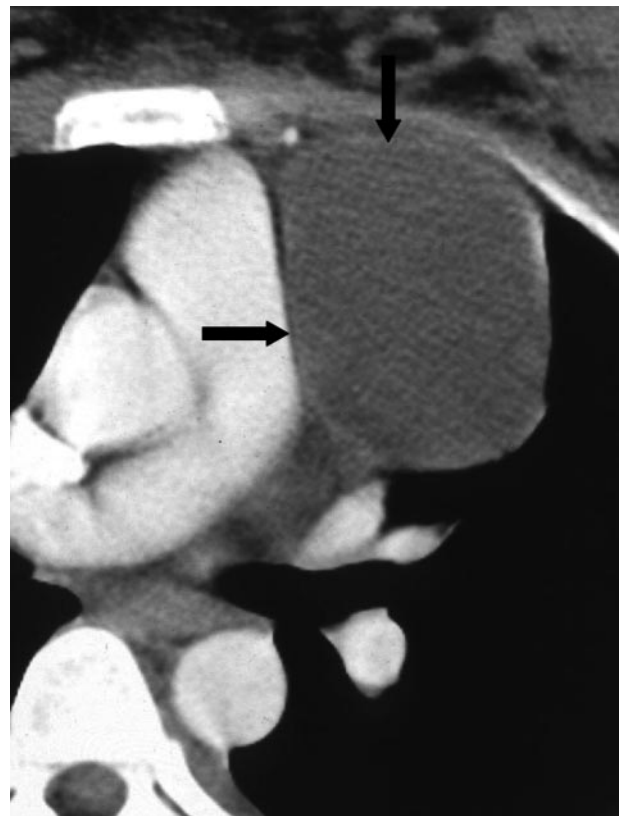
A 30-year-old woman with a unilocular thymic cyst. A contrast-enhanced CT scan shows a homogeneous cystic mass with a partially enhanced wall (arrows).
